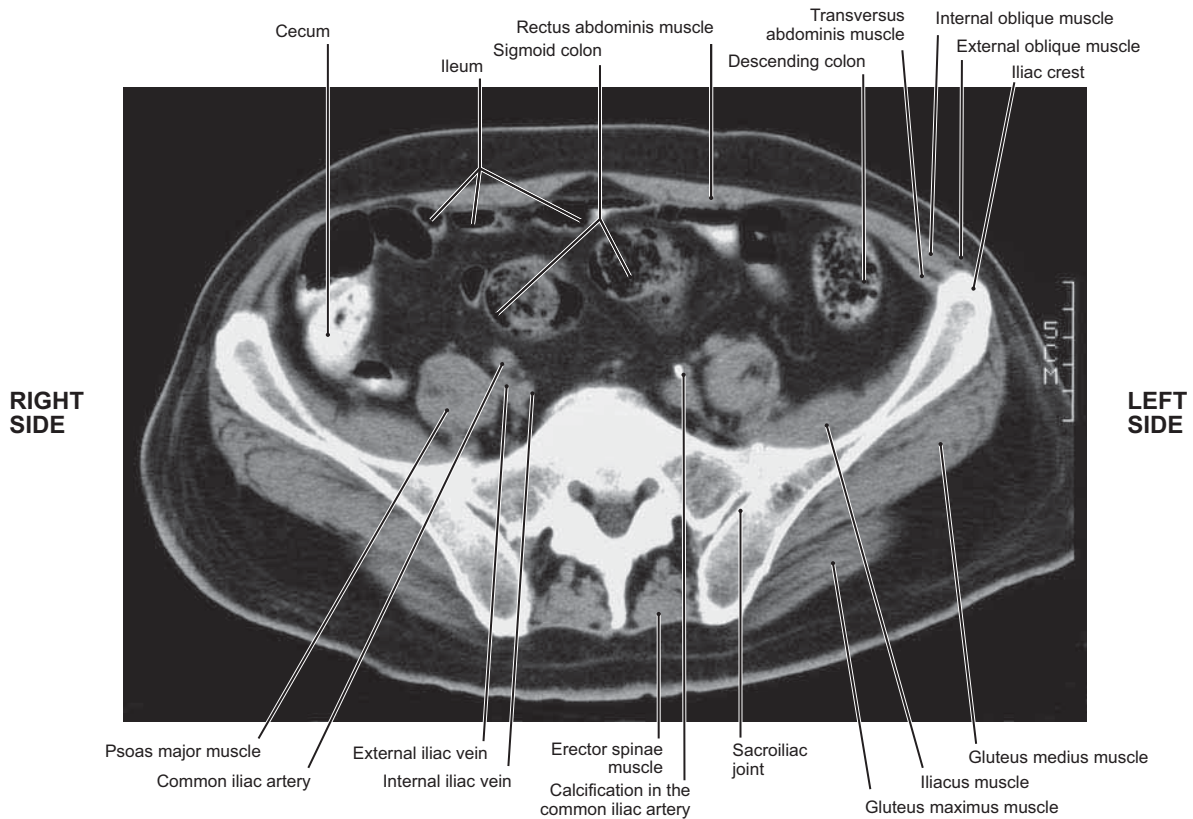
CT at the Fifth Lumbar Level (Sacroiliac Joint)
